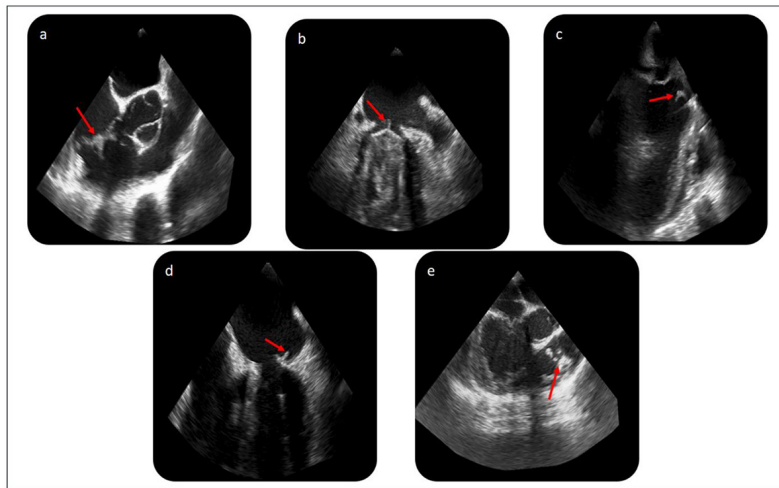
Representative Transesophageal Echocardiography (TEE) views with vegetations (red arrows). (a) Short-axis view of native tricuspid and aortic valves, (b) Mid-Esophageal (ME) 2-chamber view of a mechanical mitral valve, (c) ME long-axis view of an aortic prosthesis and native mitral valve, (d) ME 4-chamber view of the native mitral valve, (e) ME Right Ventricular (RV) inflow-outflow view of the native pulmonary valve.
